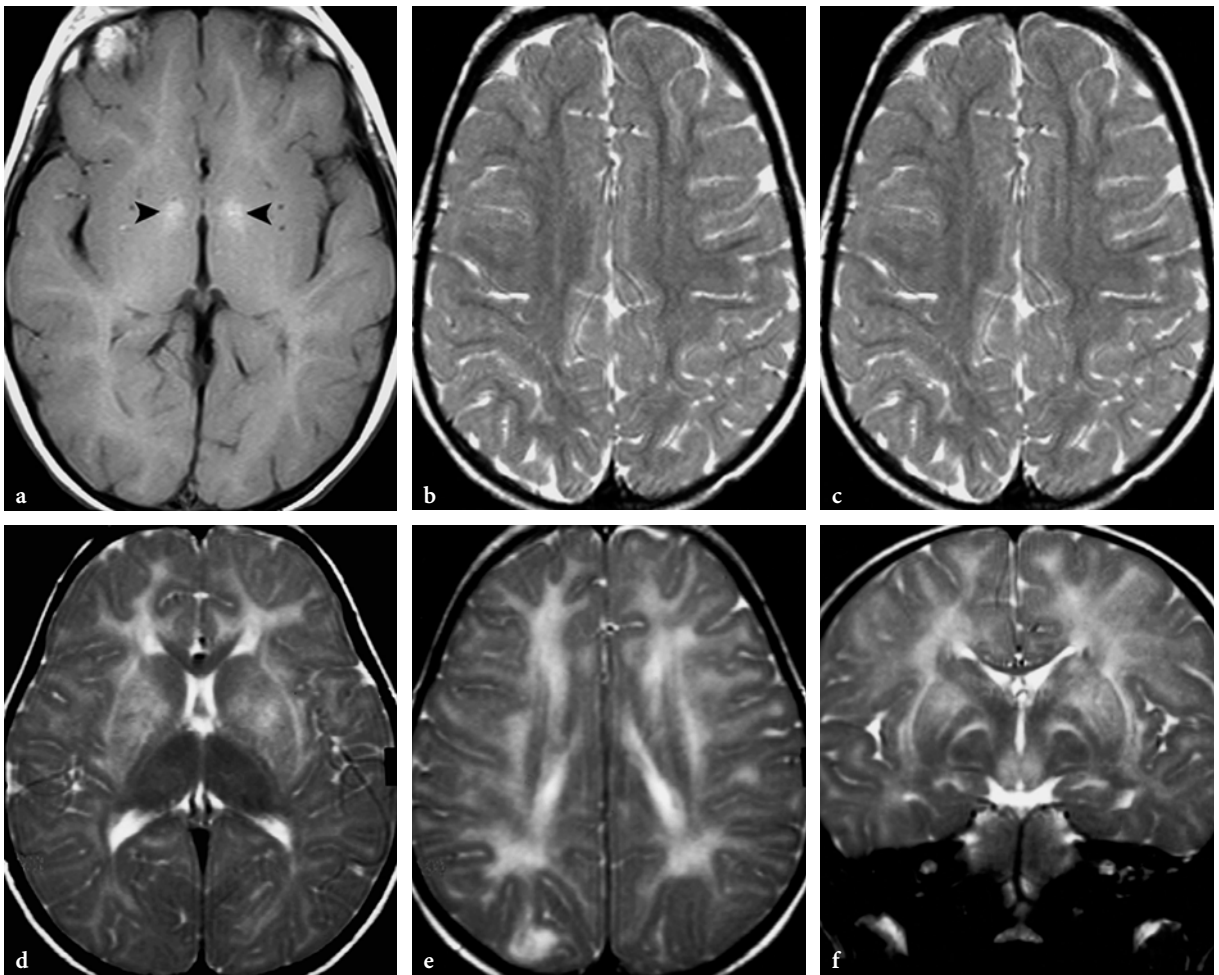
Conventional MR imaging findings in two female siblings with fucosidosis (courtesy of Dr. P. Tortori-Donati, Genoa, Italy). a–c Axial T1- and T2-weighted spin-echo images in a 5-year-old female patient. The globi pallidi exhibit a spontaneously hyperintense appearance on T1-weighted image (*arrowheads*, a). The globi pallidi and thalami show decreased signal on T2-weighted images (b, c). Diffuse paucity of myelin within the cerebral hemispheres (c). d–f Axial (d, e) and coronal (f) T2-weighted spin-echo images in the 2-year-old sister. Abnormalities are more prominent and reminiscent of GM2 gangliosidosis. The cerebral hemispheric white matter is extensively abnormal. The abnormalities involve the external and extreme capsules (d), as well as the medial and lateral medullary laminae (f). An antero-posterior gradient is suggested. The basal ganglia exhibit increased signal, but the thalami are hypointense
